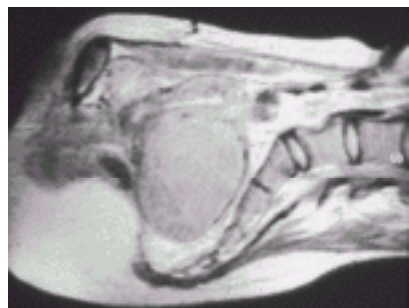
Magnetic resonance imaging of leiomyomata. This magnetic resonance image demonstrates a large leiomyoma arising from the posterior aspect of the uterus and filling the entire pelvis. It directly contacts the promontory of the sacrum.
